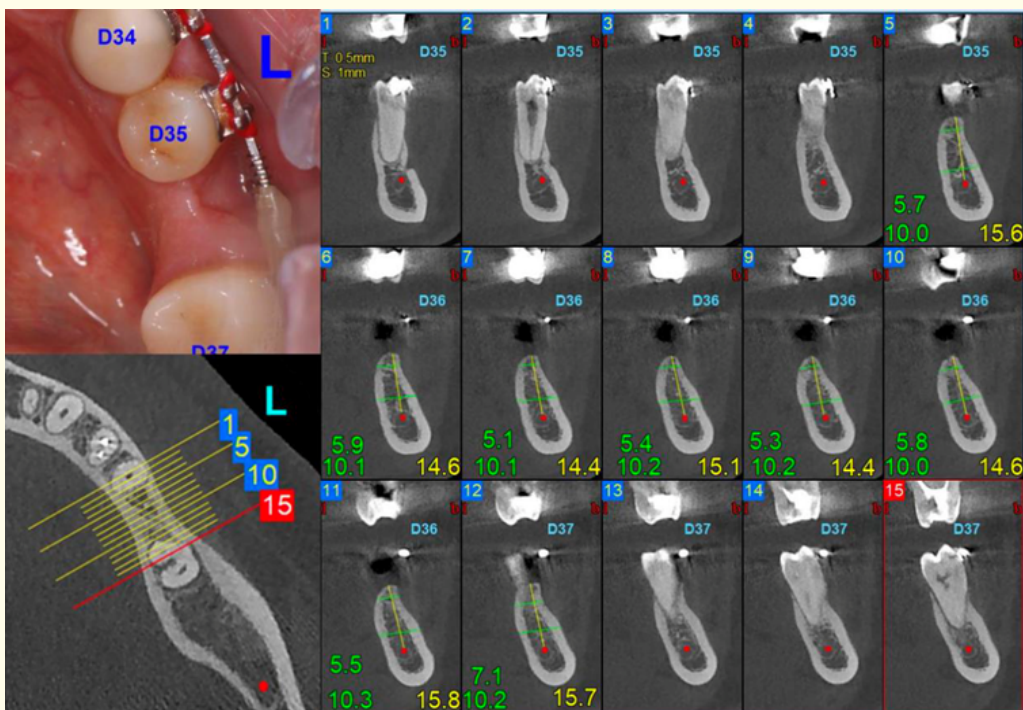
The CBCT imaging of the left side.
